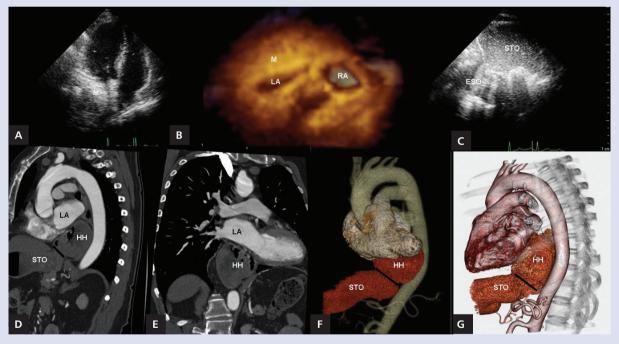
A–C. Transthoracic echocardiography; D–G. Computed tomography; RA — right atrium; rest abbreviation — see the text
